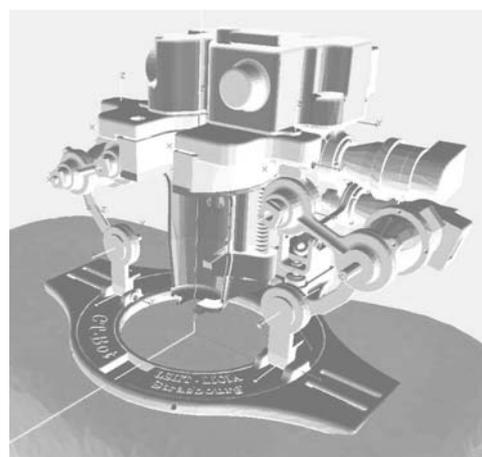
Computer Aided Design (CAD) model of the CT-Bot.
